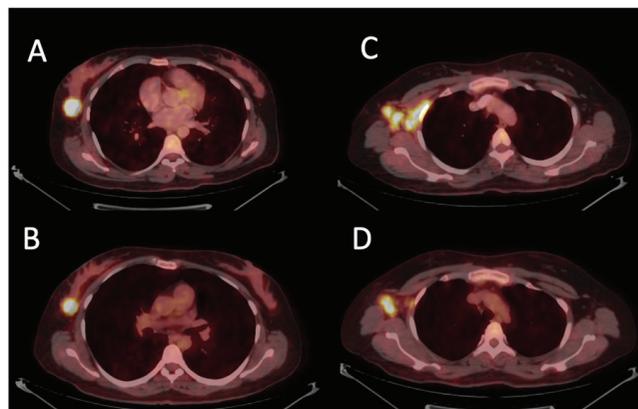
Forty one-year-old woman with triple-negative right-sided breast tumor and ALN metastases, whose pCR could not be obtained after NAC, had a primary tumor SUV_{max} value of 13.2 in the baseline PET/CT scan (A). SUV_{max} was measured as 11.8 in the interim evaluation (B). Under the partial metabolic response, the pre-treatment (C) and interim treatment (D) SUV_{max}-N were 12.3 and 8.5, respectively. ALN: Axillary lymph node, pCR: Pathological complete response, NAC: Neoadjuvant chemotherapy, SUV_{max}: Maximum-standardized uptake value, PET/CT: Positron emission tomography/computed tomography
